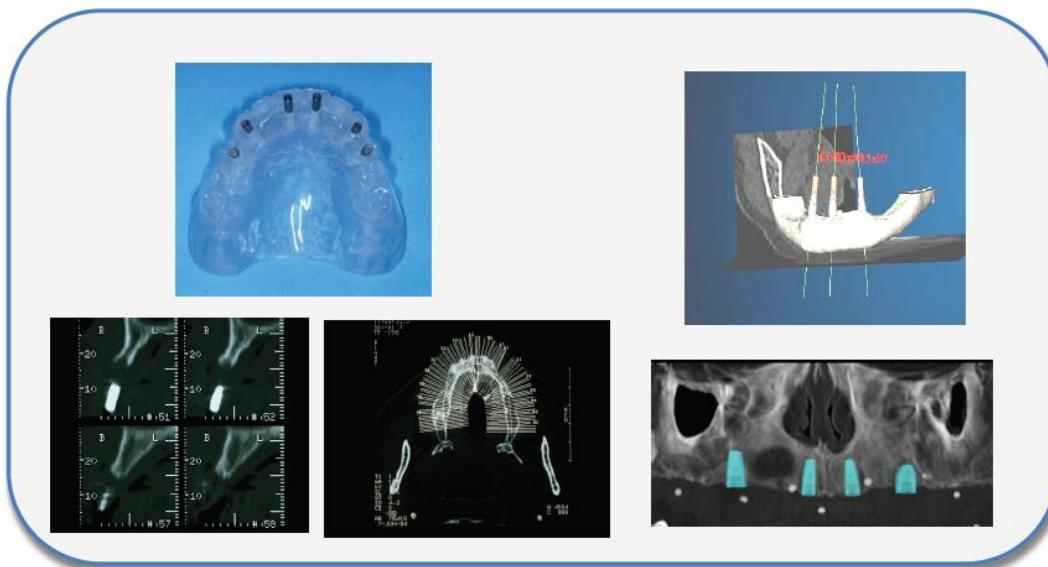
conventional planning and 3-D planning software. Radiographic analysis left top: Acryl splint of complete denture with measuring pins used as landmarks for analog radiographic analysis; bottom: CT-can slices and overview right: computer assisted planning with implant placement and 3-D or 2D visualization of prospective implant position.
